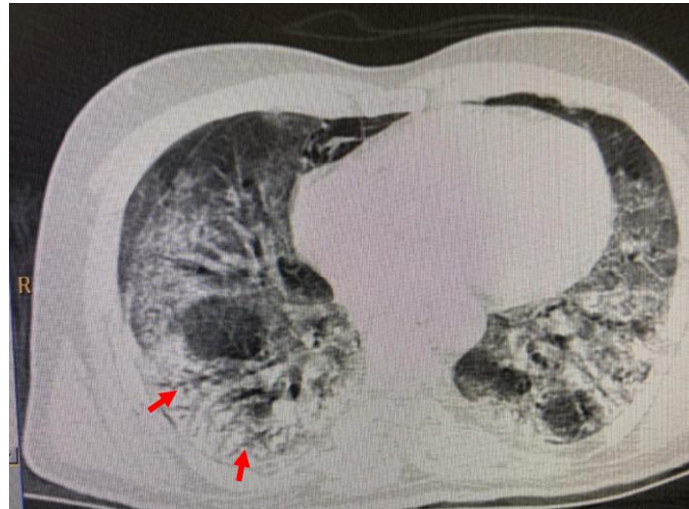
HRCT thorax of a 56 year old diabetic male patient shows patchy areas of consolidation (arrows) with adjacent ground glassing in bilateral lung fields at places.
